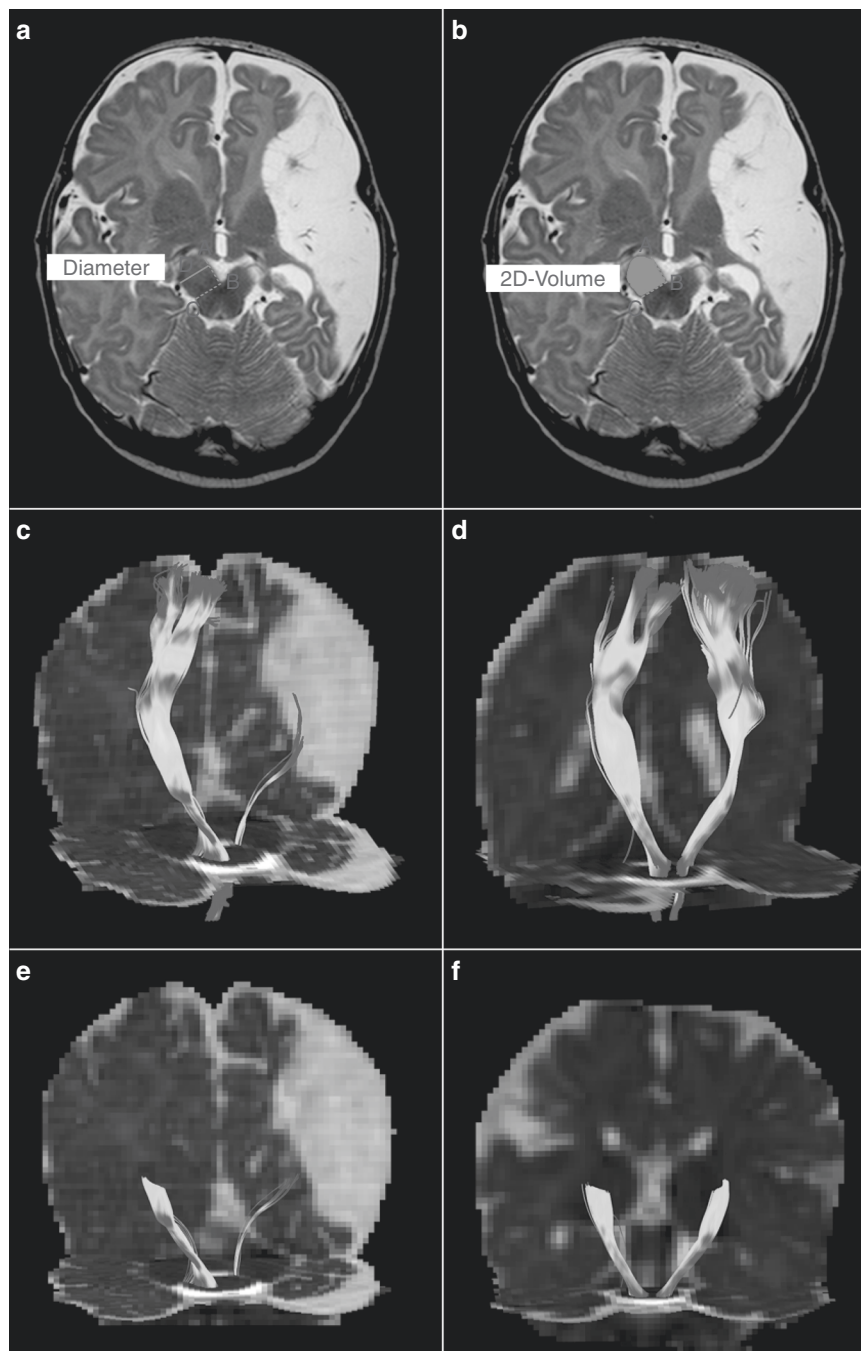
Example of MRI measurements. Cerebral peduncle measurements were performed on axial T2-weighted images (a, b). First, a line was drawn parallel to the medio-frontal part of each peduncle, toward the midbrain (a, line AB). A second line (a, line BC) was drawn perpendicular to this line, crossing the peduncle. The area fronto-lateral to this line was considered to be the 2D surface area of the cerebral peduncle (b). Finally, a third line was drawn, parallel to the second at the broadest part of the peduncle, reflecting the width of the peduncle (line D, a). Tractography in CSTs of an infant who developed USCP (c) and an infant with normal outcome (d) using diffusion tensor imaging (DTI). After tractography of the full CST, segments between the PLIC and cerebral peduncle were selected for FA measurements. Clear FA asymmetry is shown in the infant who developed USCP (e) compared to a typical developing infant (f).
